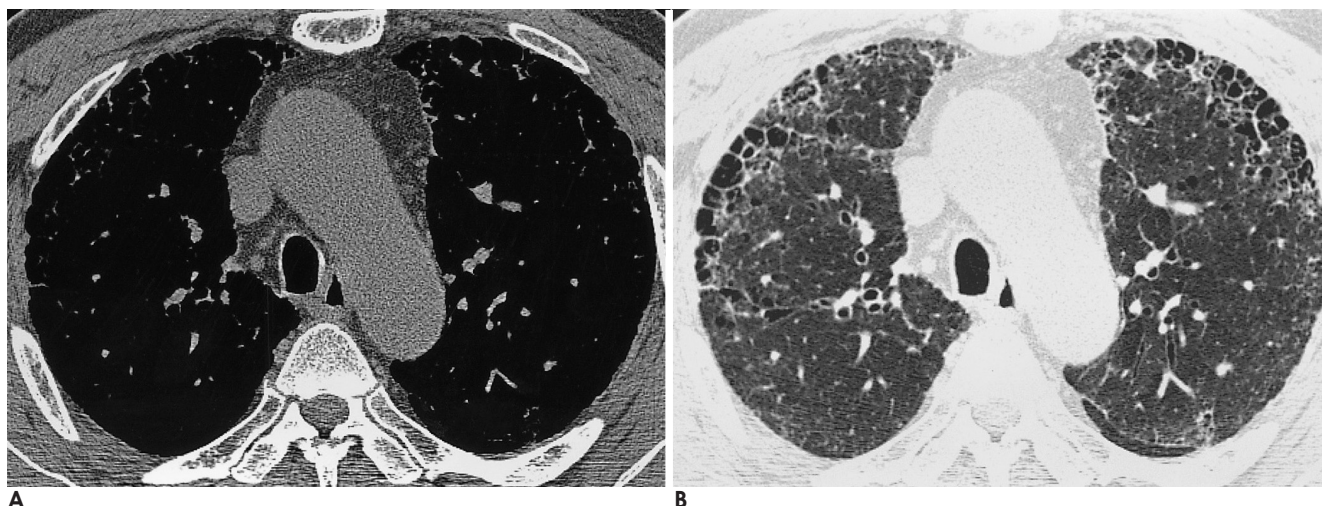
The CT section of aortic arch in a 63-year-old male with idiopathic pulmonary fibrosis.
